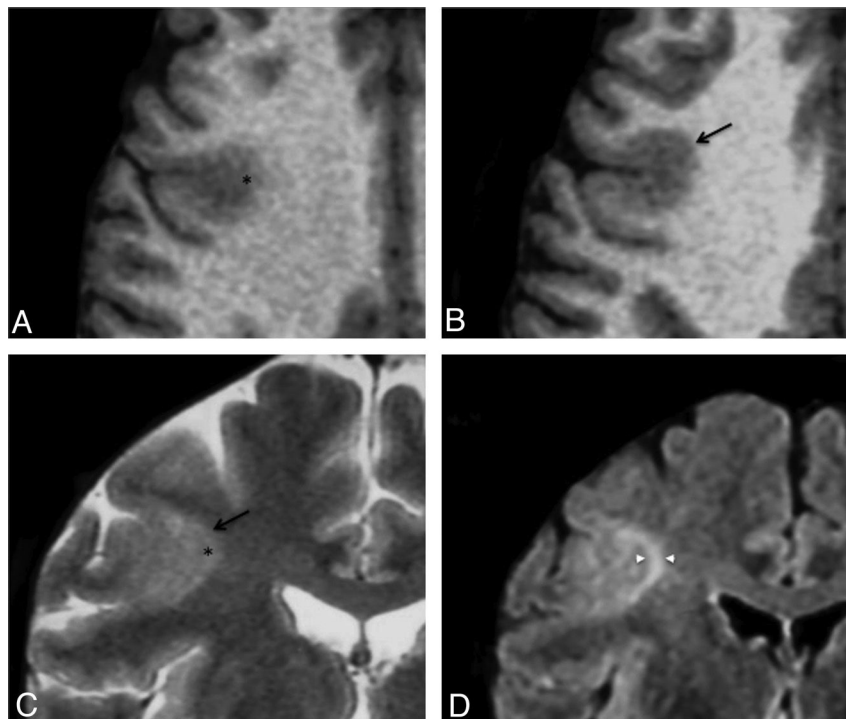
Cortical pseudothickening. Axial T1WI (A and B) and coronal T2WI (C) in a 29-year-old man with left motor seizures, onset at 3 years of age. These images show cortical thickening (arrow) and blurring (asterisk) of the gray-white matter interface of the right central sulcus. D, Coronal FLAIR image allowing cortical to be distinguished from subcortical signal increase (arrowheads).
